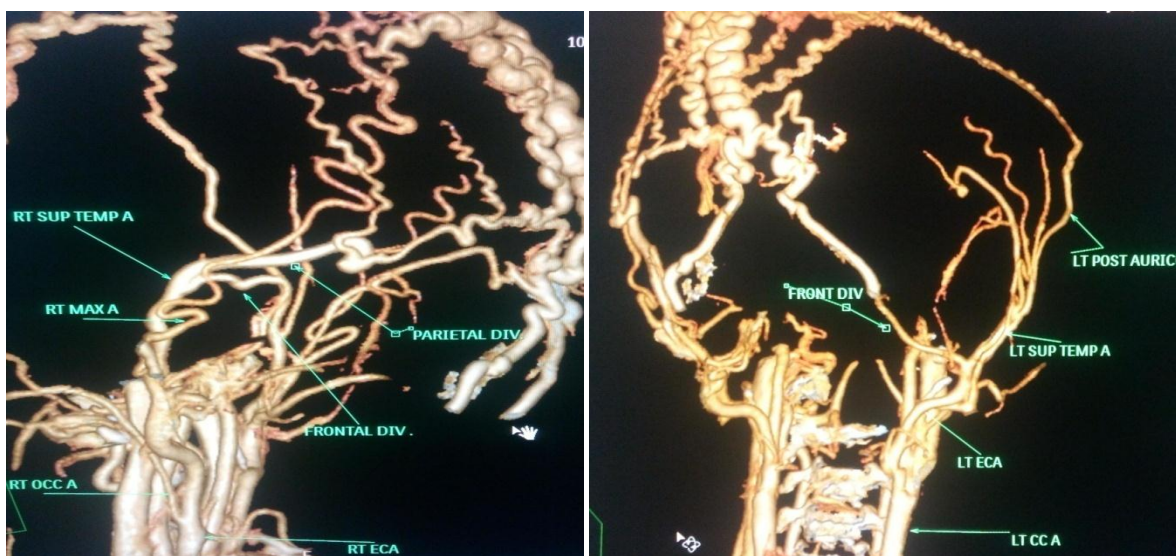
3D CT Angiography images showing the arterial feeders of the cirroid aneurysm of the scalp.
